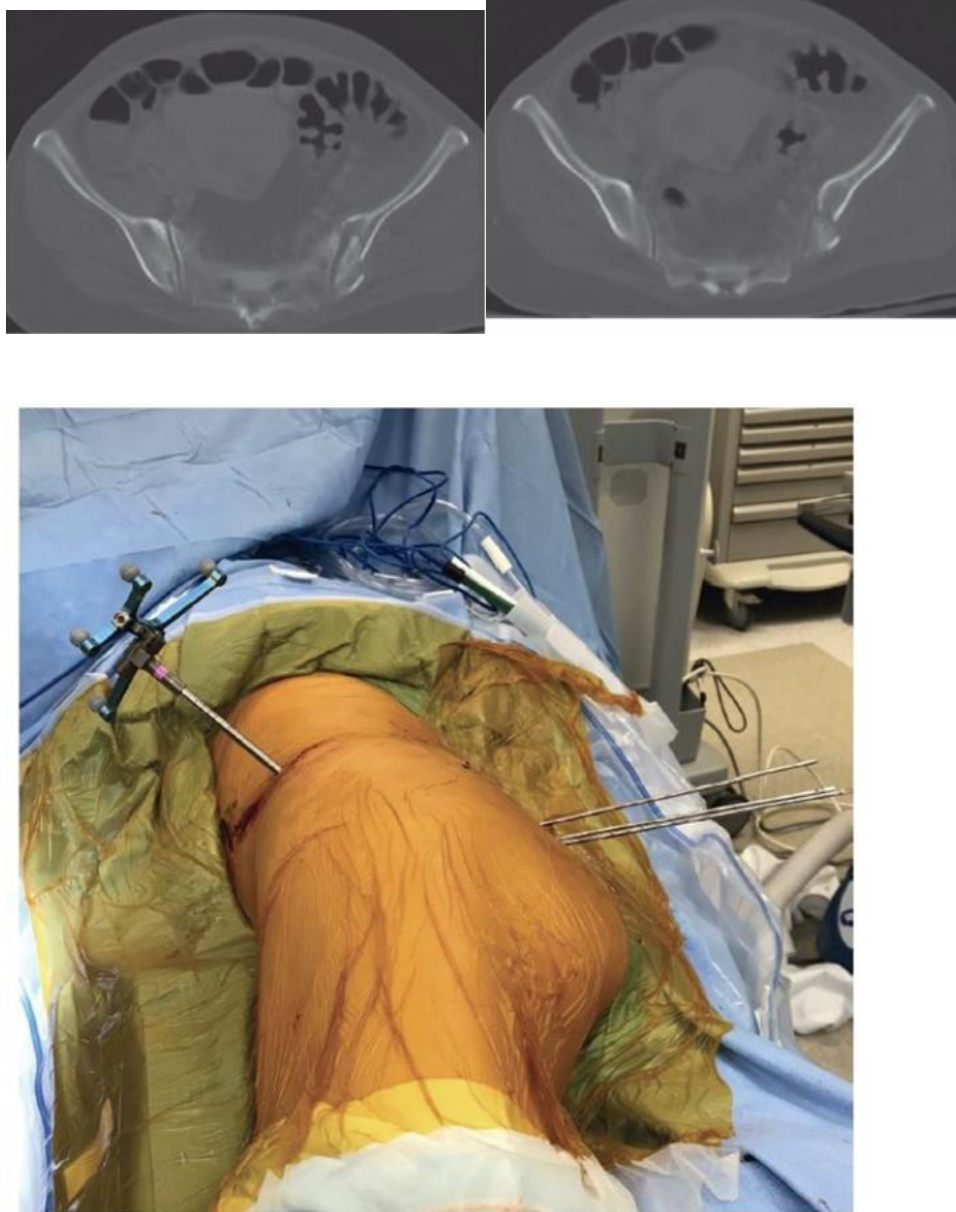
Example of CT-navigated percutaneous pelvic fixation with navigation-guided guidewire placement. 47yo female with metastatic EGFR mutant lung cancer and mildly displaced fracture through the left posterior ilium occurred 10 days after radiation (35Gy), leading to acute onset of disabling pain and inability to weight bear. Patient positioned in full right lateral position to facilitate screw insertion in the posterior left ilium. After placement of the reference frame on the anterior portion of the ipsilateral iliac crest, multiple navigated 3.2-mm guidewires have been inserted along the trajectory selected on preoperative plan.
